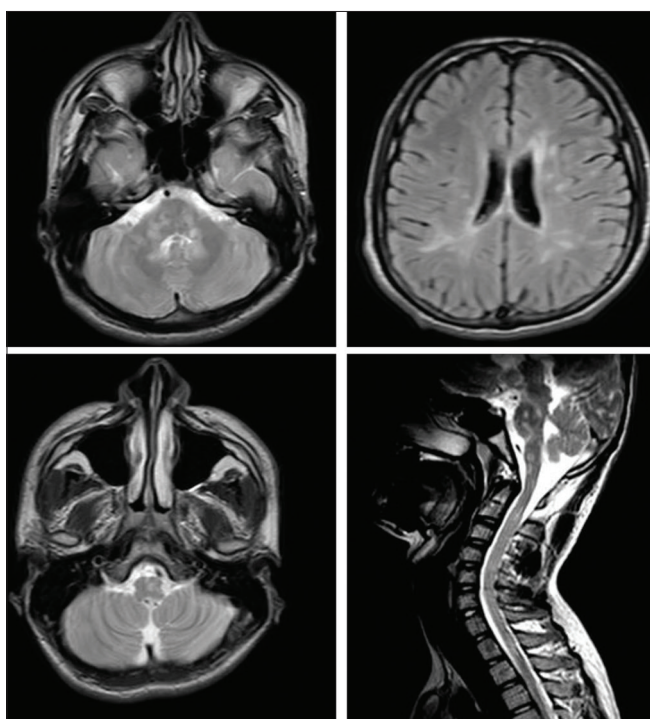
Axial T2 and FLAIR sections of brain and sagittal T2 section of cervicodorsal spine showing multiple variable-sized T2/FLAIR hyperintensities in a patient of multiple sclerosis
